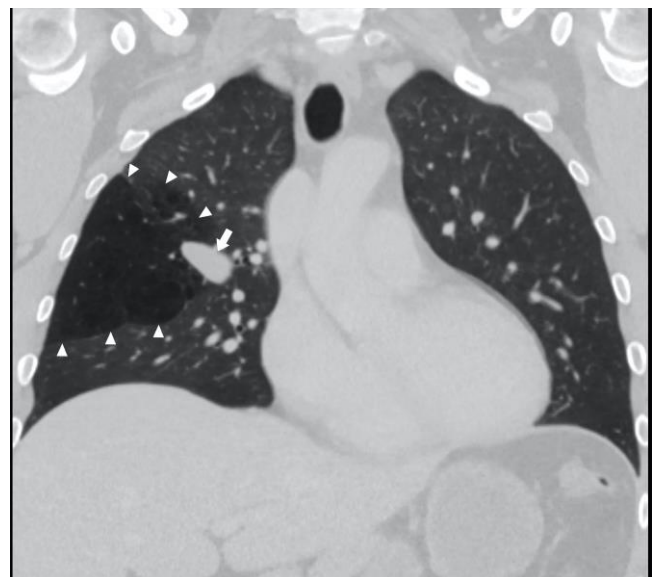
Coronal CT image in a parenchymal window showing the dilated atretic bronchus plugged with mucus (arrow) and a radiolucent area due to air trapping and oligemia in the adjacent lung parenchyma (arrowheads)
